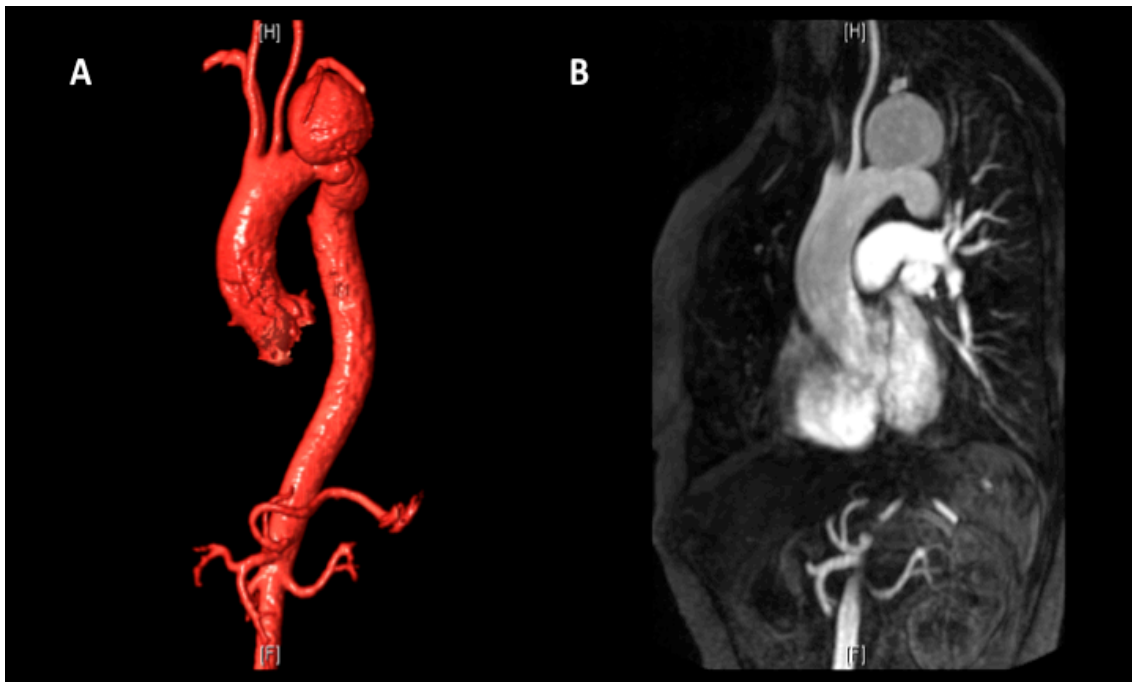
MRI in ATAs. Control MRI of a saccular post-traumatic pseudoaneurysm in a 51-year-old female 6 years after a fall. A. Three-dimensional reconstruction image shows the presence of a huge saccular aneurysm involving the origin of the LSA. B. Maximum Intensity Projection revealed compression and displacement of the LSA.
